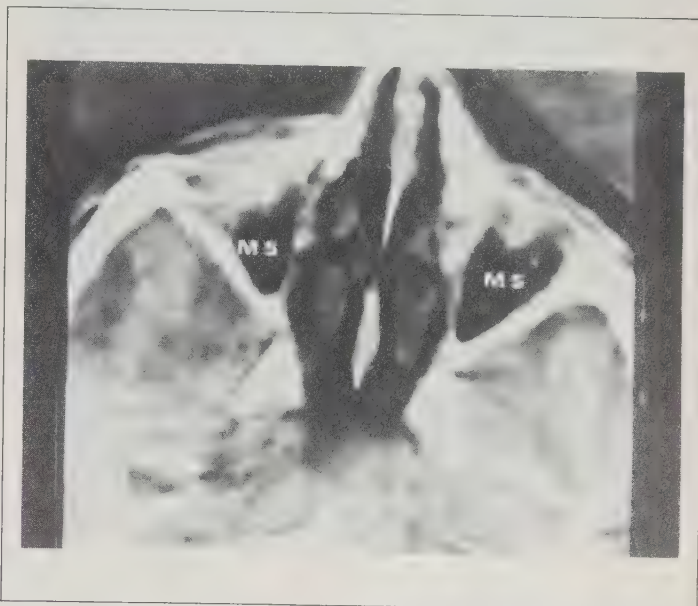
Computerized axial tomographic scan radiograph of the same patient as Fig 2. The orbital-meatal plane "cut" was taken at a level just above nasion. Note discrepancy in sizes of the left and right maxillary sinuses (MS) at this level.
